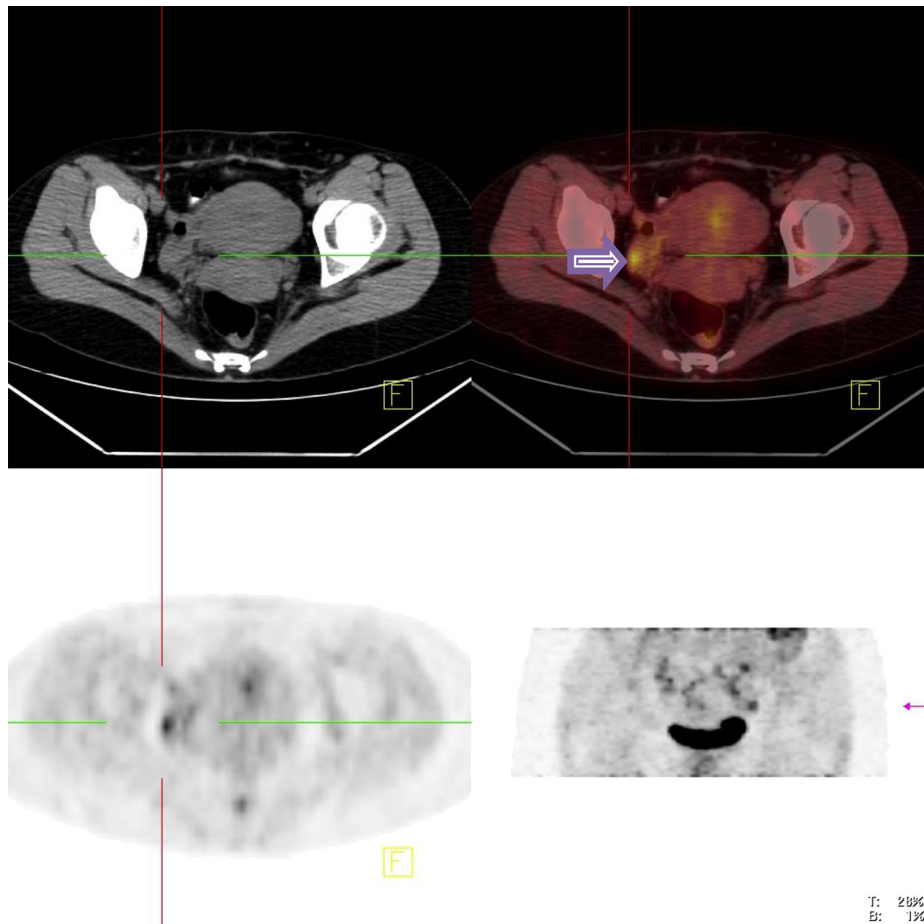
Fludeoxyglucose-positron emission tomography computed tomography (FDG PET CT) scan shows suspicious uptake and an F18 FDG avid lesion in the right lower pelvic area with evidence of suspicious recurrent choriocarcinoma.
